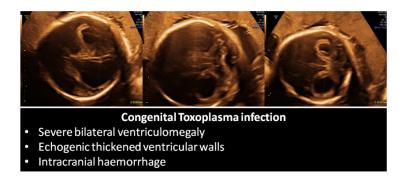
Ultrasound findings in fetuses with congenital toxoplasma infection $338x190mm \; (96 \; x \; 96 \; DPI)$
